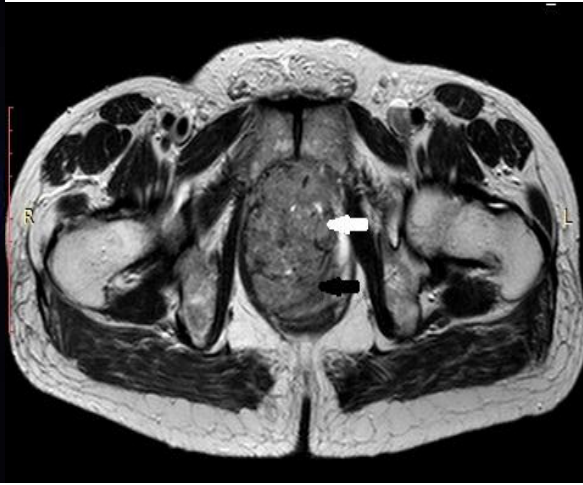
MRI-Lobulated heterogeneous masslesion [white arrow] which is hyperintense to muscle on T2 W image seems to be arising from prostate [black arrow].
